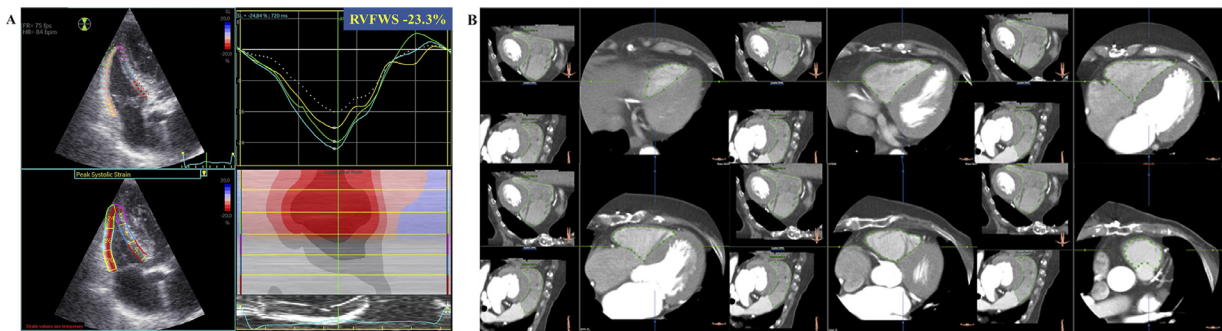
Assessment of RV systolic function with speckle tracking echocardiography and dynamic computed tomography. (A) Measurement of right ventricular free wall longitudinal strain (RVFWs) using speckle tracking echocardiography. According to the recommendation, 6 right ventricular segments were traced and RVFWs was calculated as an average of the longitudinal strain of the 3 free wall segments. (B) Assessment of right ventricular volumes according to computed tomography (CT). The endocardial border of the right ventricle was traced every 4-mm slice on CT and the end-diastolic volume, end-systolic volume, and ejection fraction were measured.
